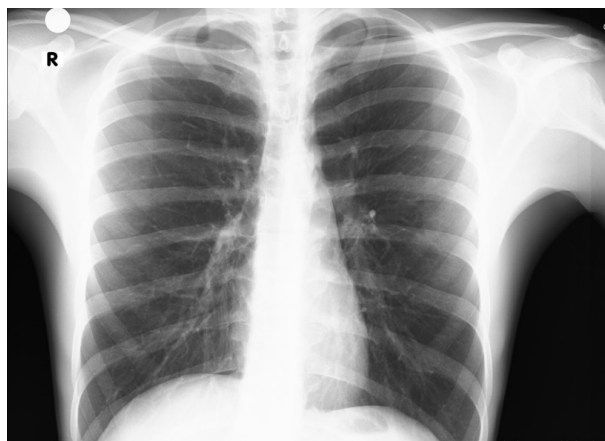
Repeat chest radiograph showed a significant reduction in the pneumomediastinum after 4 days.
